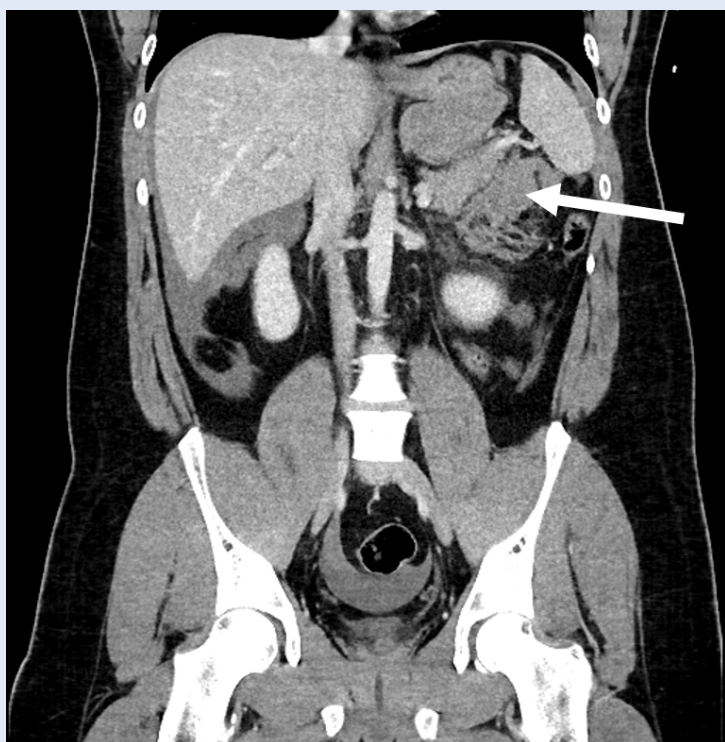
CT scan of the abdomen, coronal view. The arrow points at bleeding by the tail of the pancreas.
